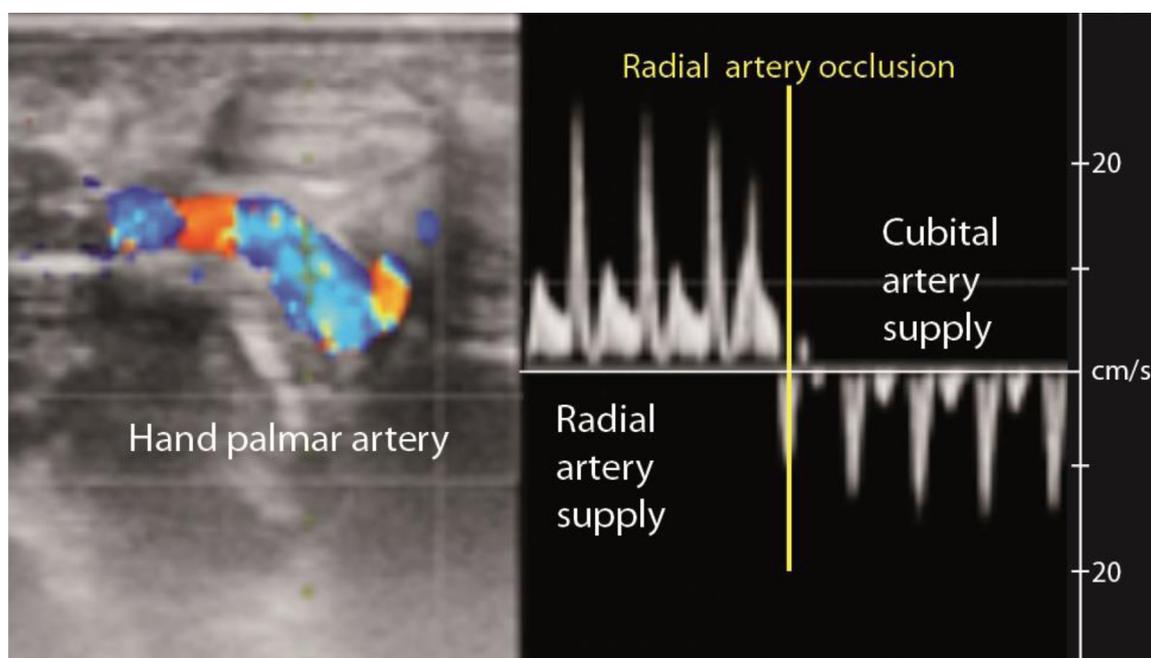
Substitution by the ulnar artery after interruption of the radial arterial supply of the hand. Pulsed Doppler shows that the cubital artery immediately compensates when the radial artery blood flow is absent (P. Zetlaoui's Personal data).
